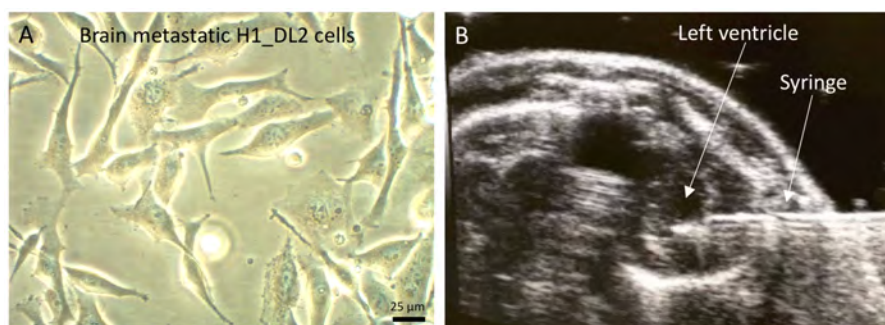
Ultrasound guided intracardiac tumour cell injections. A: H1_DL2 cells. B: Axial ultrasound frame of the left cardiac ventricle and the insulin syringe while injecting tumour cells.
